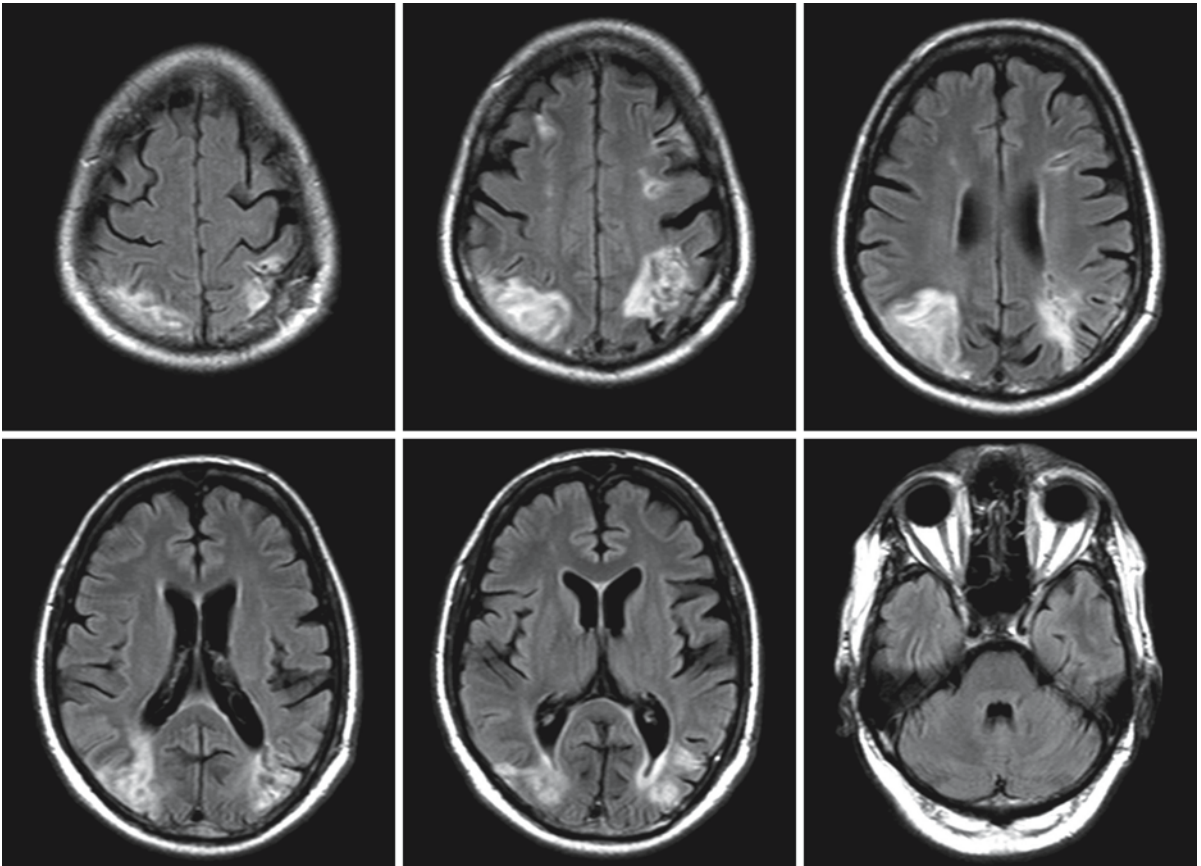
The *first two rows* contain the FLAIR images of a 52-year-old man with hypertensive encephalopathy, showing the common MR pattern of PRES lesions. The *third and fourth rows* show Trace diffusion-weighted images ($b = 1000$), with bright spots in the parieto-occipital area, more extensive on
